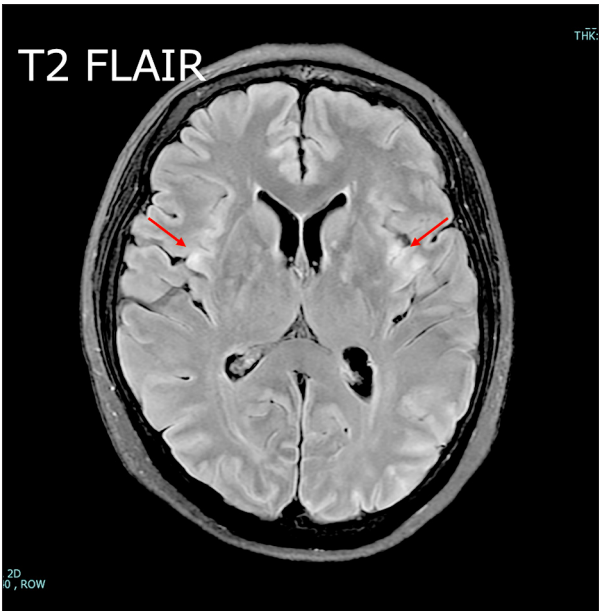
Brain magnetic resonance imaging scan at the onset of encephalopathy. T2-weighted fluid-attenuated inversion recovery (FLAIR) images showed bilateral cortical and limbic hyperintense lesions, including in the insular and temporal regions, providing clinical support for HHV-6 encephalitis.
